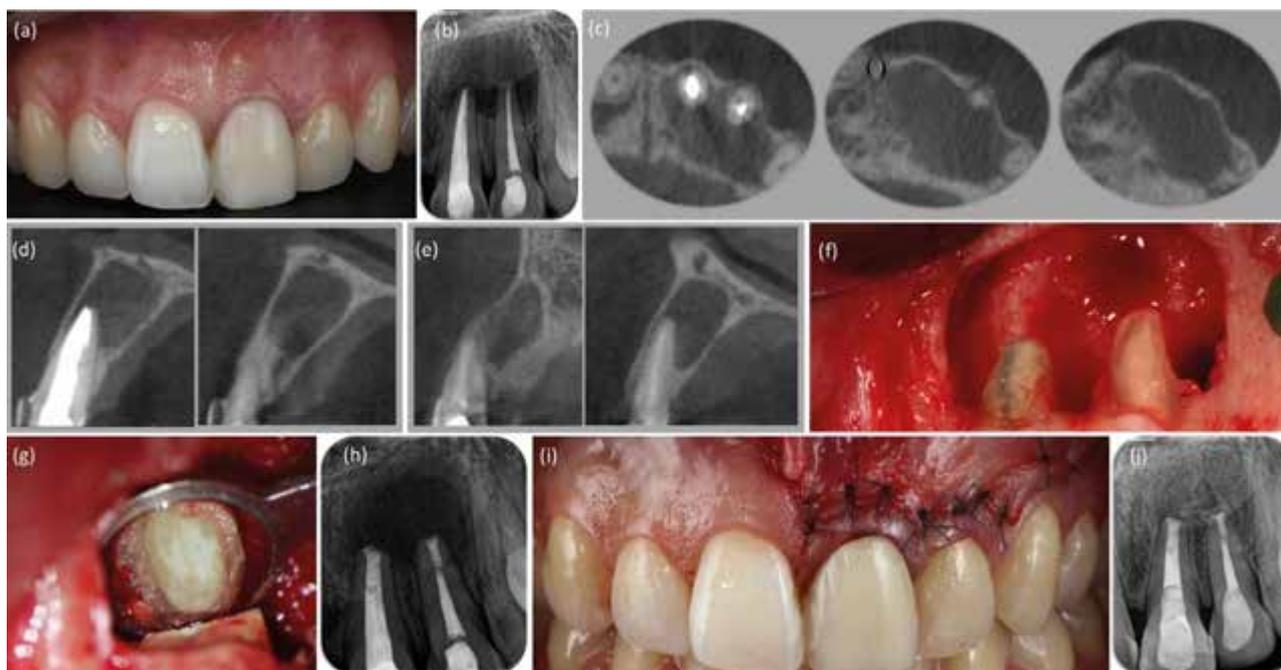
(a) A clinical image of the left maxillary central and lateral incisor subjected to endodontic surgery. (b) A periapical radiograph showing an apical lesion in teeth 21 and 22. (c, d, e) A cone beam computed tomography (CBCT) scan (CS 9000 3D; Carestream Health, Rochester, NY, USA) was performed before endodontic surgery. (C) Sagittal and axial images confirmed a circumscribed apical lesion. Note that the apical lesion affected neither the buccal nor palatal cortical plates. (f) A submarginal (Ochsenbein-Luebke) flap was raised to gain access and treat the apical lesion. Final size of the osteotomy. (g) Mineral trioxide aggregate (White ProRoot MTA, Dentsply Maillefer) root-end – filled apex. (h) An immediate post-operative radiograph. No bone regeneration techniques were required. (i) The flap was repositioned and sutured tightly with 5 × 0 monofilament sutures. (j) Two-year follow-up radiograph showing almost complete healing.
